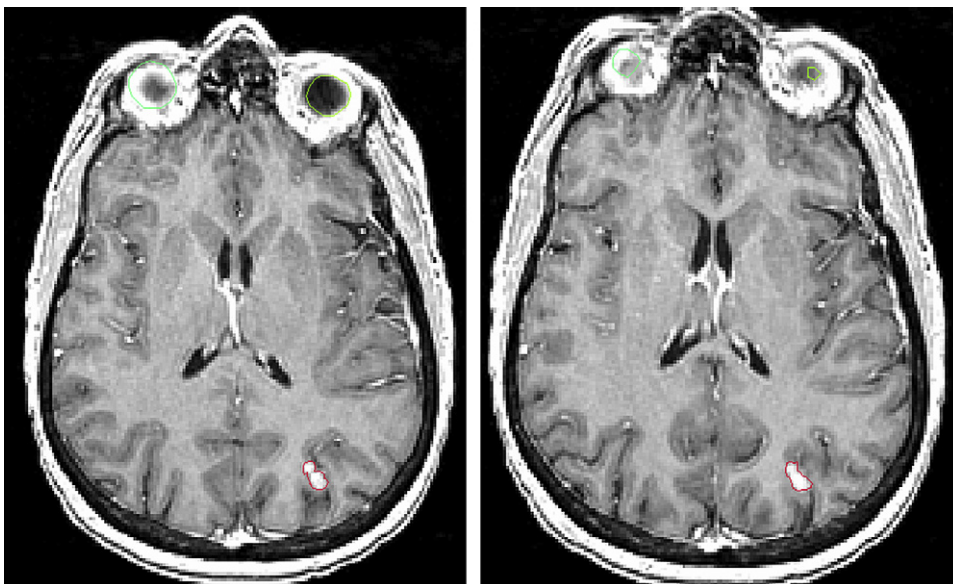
Magnetic resonance imaging sections on which the target volume, the contrast-enhancing lesion in the posterior occipital lobe, was to be outlined.
